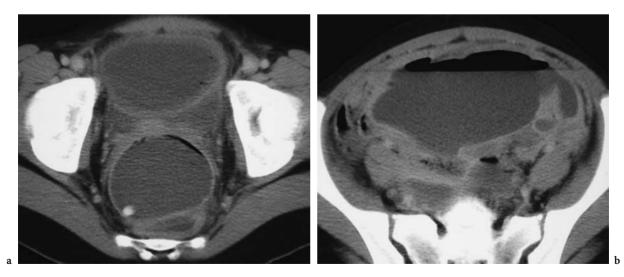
CT of the abdomen in a 12-year-old girl with a perforated appendicitis. a A large collection of fluid in the abdomen with an appendicolith seen low in the pelvis. b Fluid extending throughout the abdomen with an associated air-fluid level
